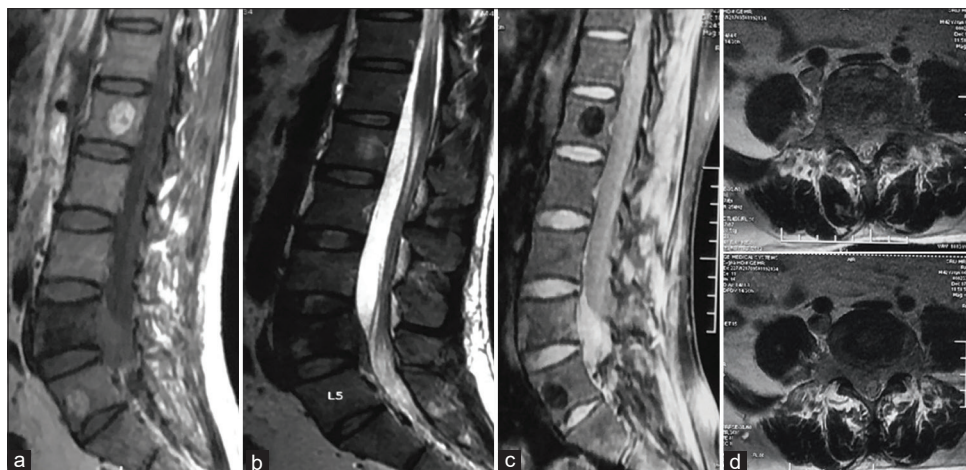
(a and b) Sagittal T1 and T2 weighted magnetic resonance imaging respectively showing heterogeneous signal intensity and mild collapse of L4 vertebral body with extradural collection compressing the dura, (c) Sagittal STIR sequence showing hyperintense lesion involving L4 body with extension into the epidural space, (d) Axial T2 weighted magnetic resonance imaging showing near complete occlusion of the spinal canal
